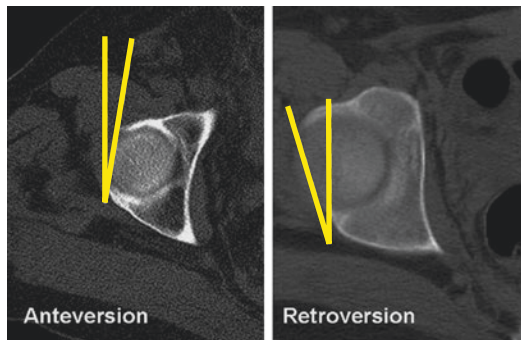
Axial CT images through the cranial aspect of the hip showing anteversion and retroversion
